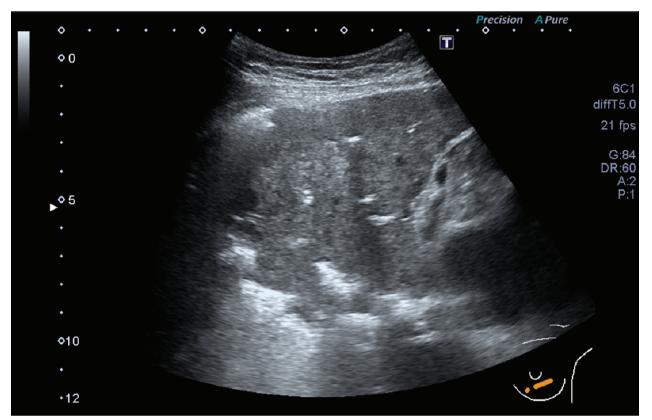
Thoracic sonography showed a consolidative mass lesion, with air bronchogram.
